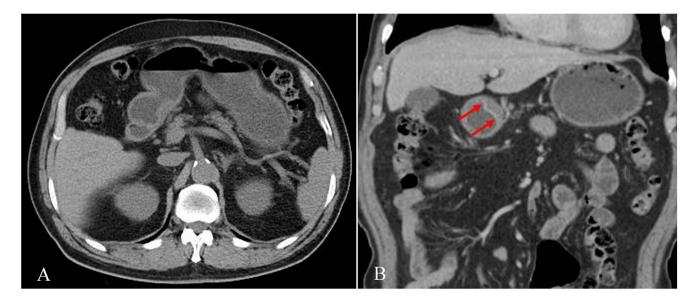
A typical case (female, 51 years old) with well-enhanced mucosal thickening of the gastric wall on CT (T1a stage, adenocarcinoma, moderately differentiated). (A) Plain CT image: Local gastric wall thickening in the lower 1/3 of the stomach. (B) Enhanced CT image: The lower 1/3 of the stomach exhibited well-enhanced mucosal thickening of the gastric wall (red arrows).
